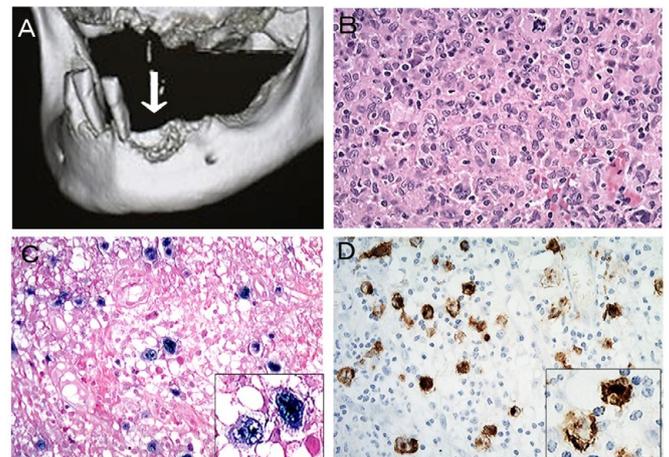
Age-related lymphoproliferative disorder [72]. 3D-CT view showing irregular bone resorption surface, the so-called "moth-eaten" appearance, and remaining-teeth with severe periodontitis are noted (a). Bizarre giant cells with Hodgkin and Reed-Stemberg-like appearance are evident in areas of granulomatous proliferation (b). The bizarre giant cells are positive for EBER (c) and LMP-1 (d).
